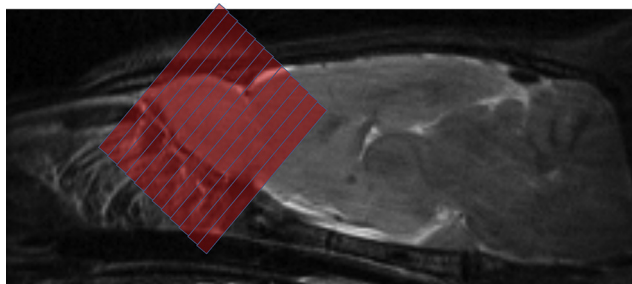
OB and cribriform plate observed *in vivo* via MRI on the orientation of median sagittal. The red oblique bars is the oblique coronal direction of scanning method applied in this study to observe OFs.
